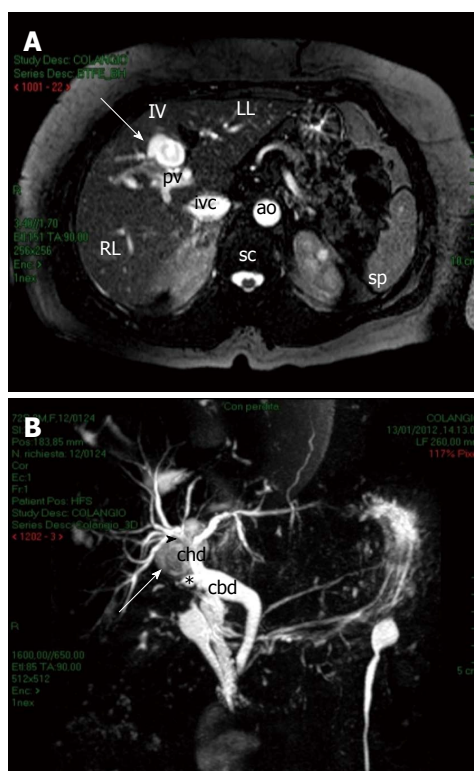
Biloma features on magnetic resonance imaging. A: On T₂-weighted images, the biloma appeared as a hyperintense lesion located in the IV hepatic segment (arrow); B: Contrast enhanced magnetic resonance cholangiopancreatography shows the biloma as a well-defined, rounded lesion (arrow) arising posteriorly to the confluence of right and left hepatic ducts into the common hepatic duct (arrowhead) in proximity to the stump of the remnant cystic duct (star). RL: Right hepatic lobe; LL: Left hepatic lobe; IV: Fourth hepatic segment; ivc: Inferior vena cava; ao: Aorta; pv: Portal vein; sc: Spinal column; sp: Spleen; chd: Common hepatic duct; cbd: Common bile duct.
